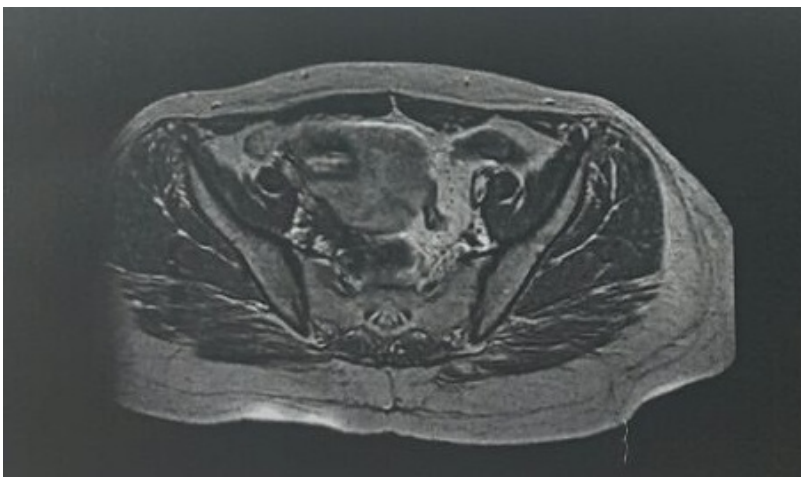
Coronal view of pelvic MRI
